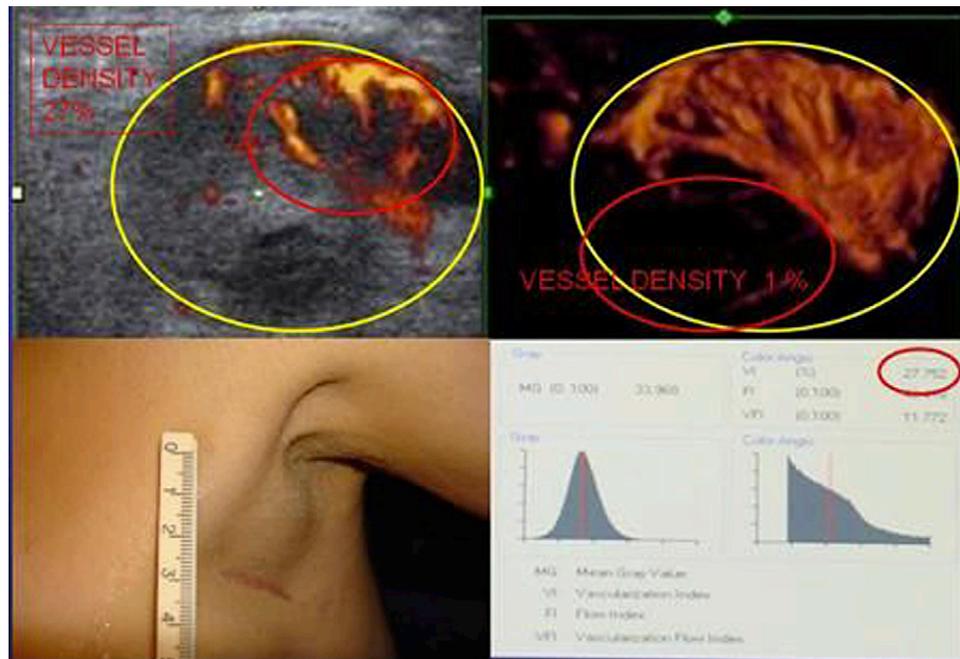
Three-dimensional Doppler sonogram with vascular index histogram. Metastatic melanoma to axillae. Recurrent nodal 12-cm³ volume of tumor shows 8 cm³ of necrotic tissue with vascular index of 1% and 4 cm³ of hypervascular cancer with vascular index of 27%. Follow-up studies may be used to compare changes in vessel density posttherapy.
